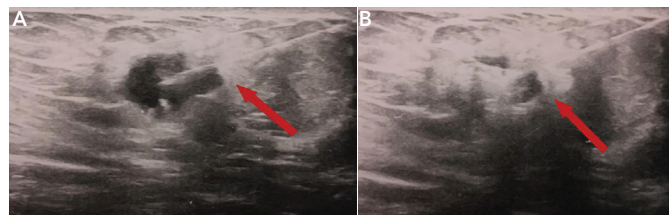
Radioguided occult lesion localization performed with ultrasonographic guidance. A. The needle can be seen inside the lesion (red arrow). B. After radionuclide injection, there is increased echogenicity in the lesion (red arrow)
